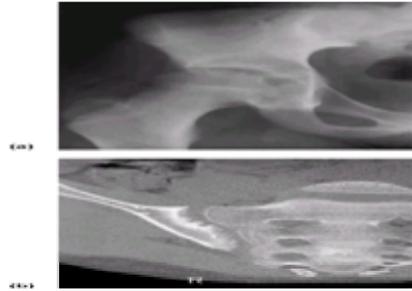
Juvenile spondylarthropathy in an 11-year-old boy. (a) Plain film: lateral subluxation of the femoral head with lateral narrowing of the joint space. Sclerosis of the sacroiliac joint. (b) CT: sclerosis, irregularity, and erosion of the sacroiliac joint.
